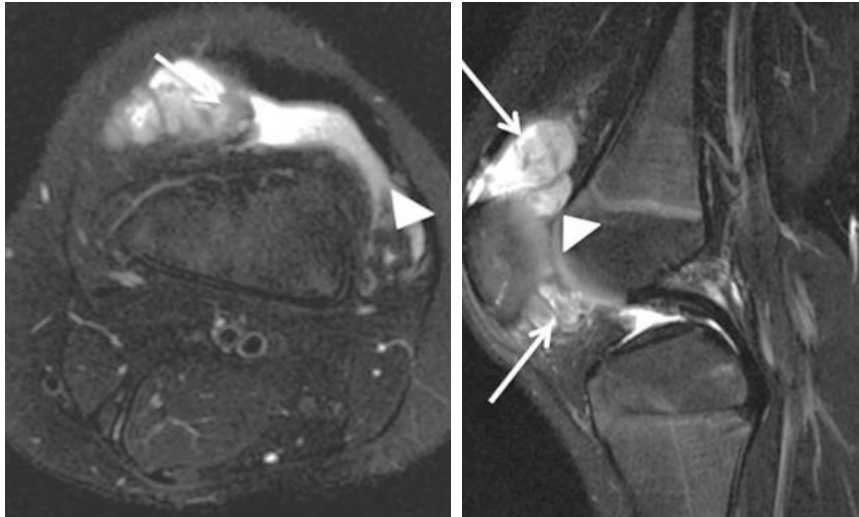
MRI appearance of the lesion
